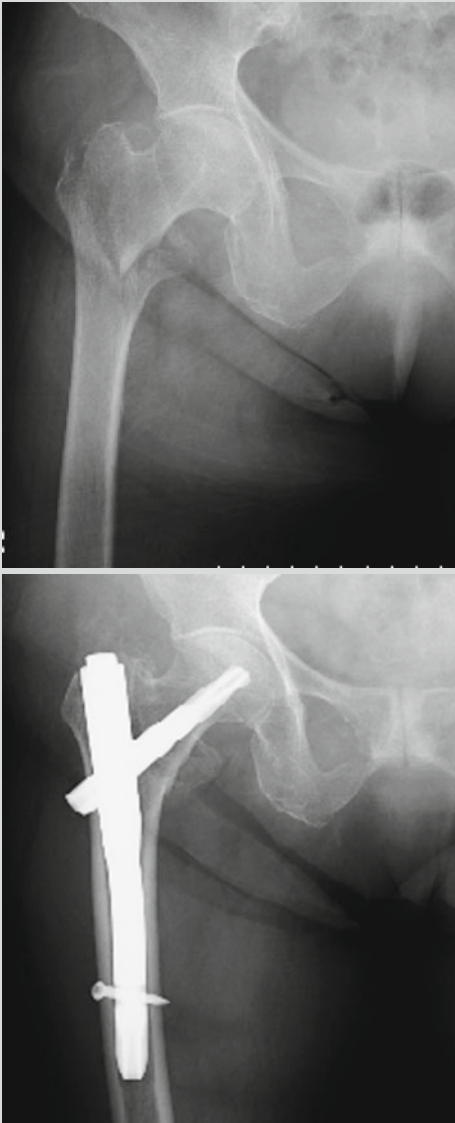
(Upper) Anteroposterior X-ray of a 75-year-old female patient. Right trochanteric fracture was recognized on radiological findings. (Lower) Surgical treatment with intramedullary nail was undertaken successfully
